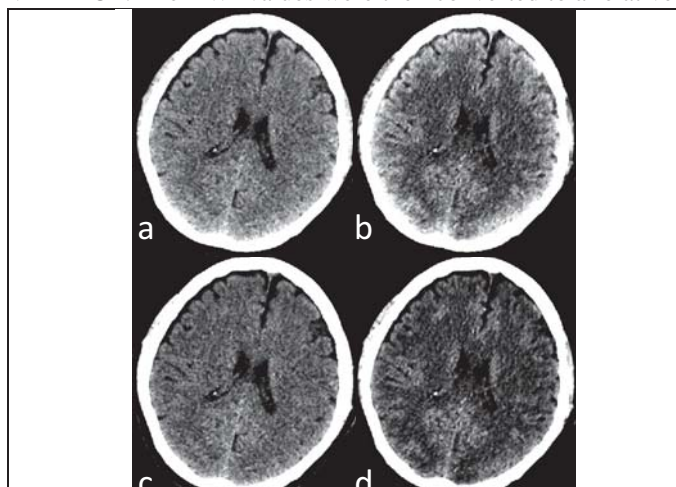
NE-DE-CT images of an acute stroke patient, reconstructed by the old iBHC (iBHC1) (A,B) and the new iBHC (iBHC2) (C,D). (A,C) High kV images, (B,D) low kV images. Biases (or whitening cupping artifacts) near the skull, observed with iBHC1 (A–B), were significantly improved by iBHC2. Window width is 50 HU.
